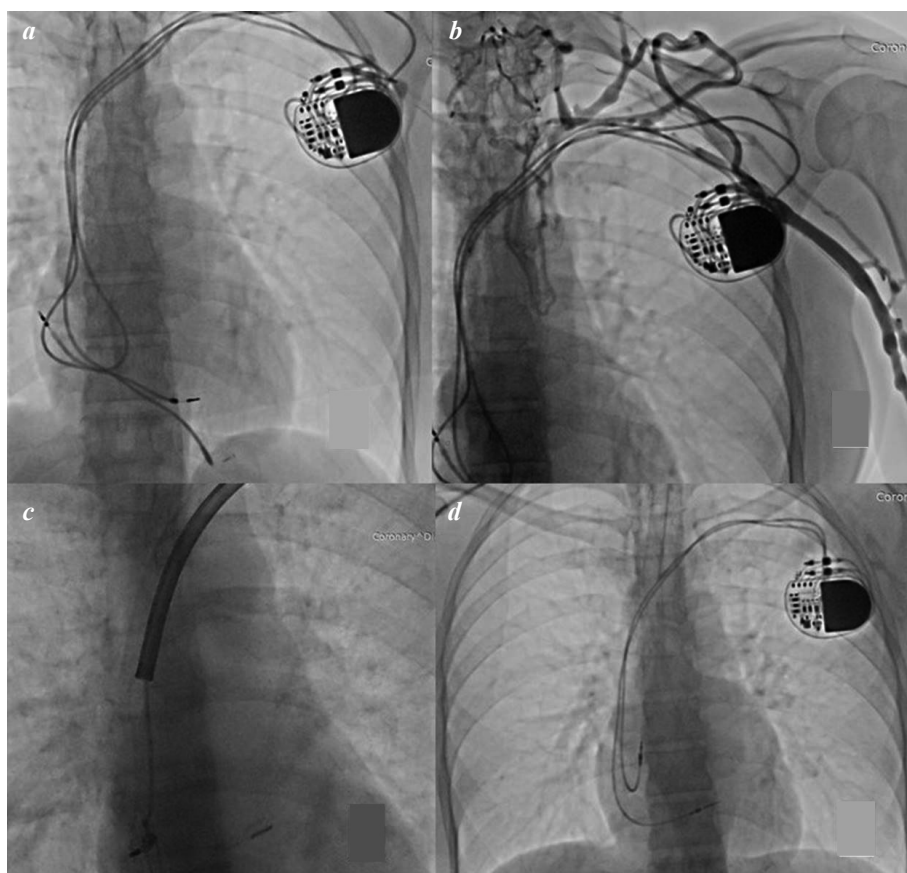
Extraction of broken lead with recanalization of occluded vein and new lead implantation. *a* - initial chest X-ray; *b* - venography, revealed occlusion of subclavian and innominate veins; *c* - fixation of the lead with endovascular snare system, femoral access for recanalization of the vein with a rotary dilator, *d* - chest X-ray after procedure, implanted new leads.
